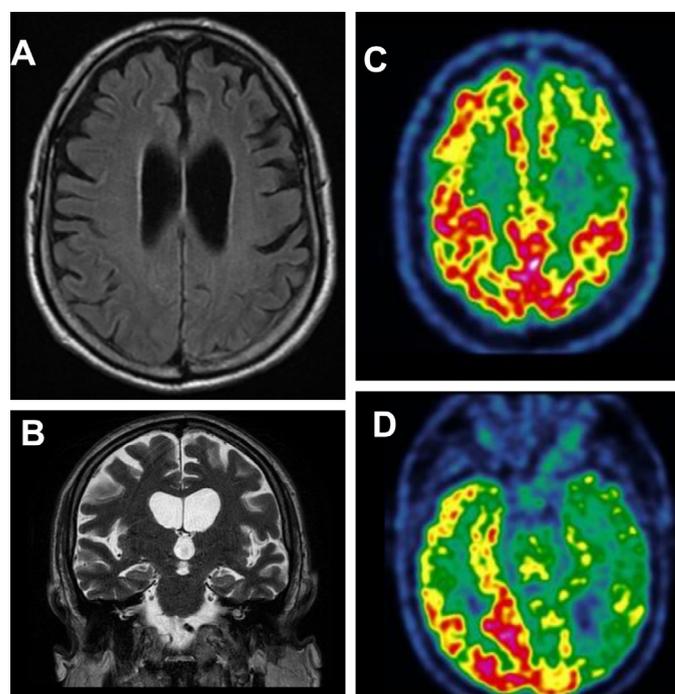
Brain MRI and FDG-PET of the patient. The MRI shows global atrophy predominating in the frontal lobe (A) and a Scheltens score at 2 (B). The FDG-PET shows severe and asymmetric brain hypometabolism, in the left frontal (C) and temporal (D) lobes, with relative respect of the parietal cortex (C).
